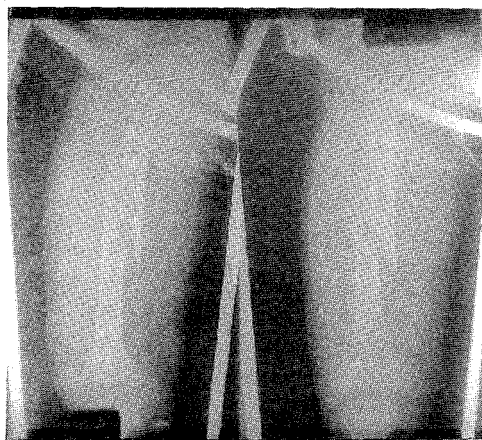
The radiograph shows the fracture with the Splint in situ. Note the improvement in the overriding of the fracture.
